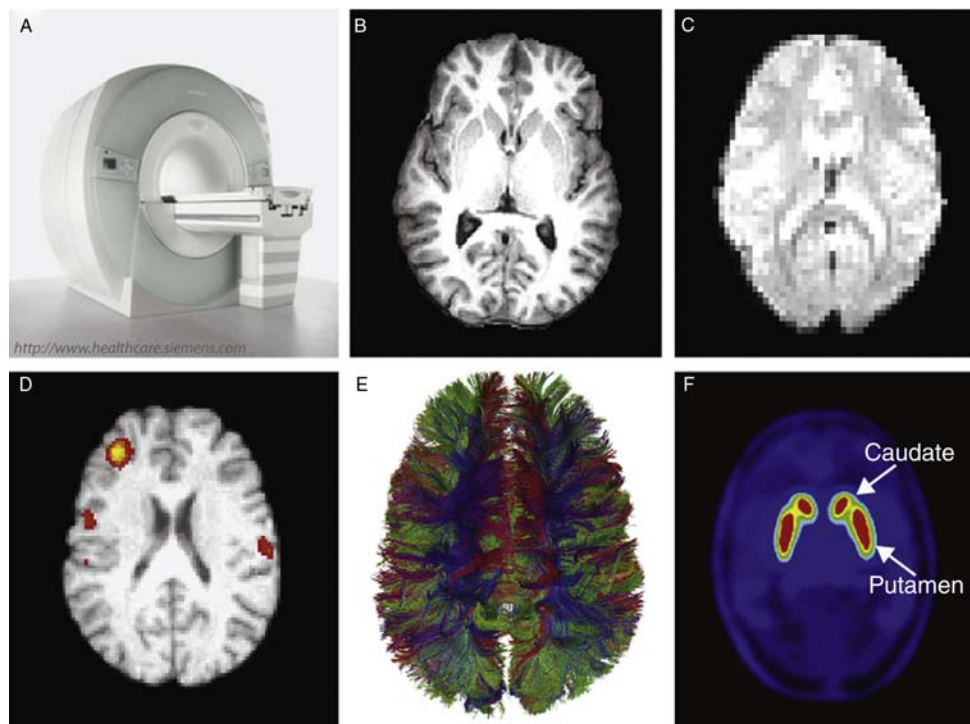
Maps of the brain vary with the type of signal detected. In (A) magnetic resonance imaging (MRI), the signal typically arises from variation in magnetic properties of hydrogen atoms across different brain tissues, producing (B) high-resolution (~ 1 mm) structural images that delineate structures such as *white* vs. *grey* matter, deep nuclei, bone and ventricles. MRI can also be used to detect brain function by measuring the oxygenation level of blood hemoglobin. The resulting images (C) are of lower resolution (~ 3 mm) at the gain of higher temporal resolution. Comparisons of the resulting images across tasks or states reveal (D) the locations of task-specific changes in brain metabolism. Localization of these changes is improved by overlaying the activation maps onto a structural image. (E) Diffusion MRI is sensitive to hydrogen movement within *white* matter, which can be used to map fiber tracts that connect *grey* matter in the cortex. An alternate measure of brain function is shown in (F). Here the binding potential of D2-like dopamine receptors for the radioactive tracer [^{18}F] fallypride is revealed using positron emission tomography (PET). The density of the receptors increases (hot colors like *red* and *yellow*) in caudate and putamen structures of the basal ganglia compared to other parts of the brain (*blue*). Figure (D) has been provided courtesy of E. London, UCLA. Figure (E) has been provided courtesy of J. Brown, UCSF.
